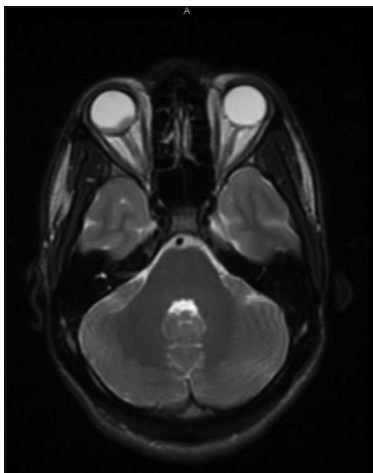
Axial view of head magnetic resonance imaging demonstrating a mass at the posterior right globe
